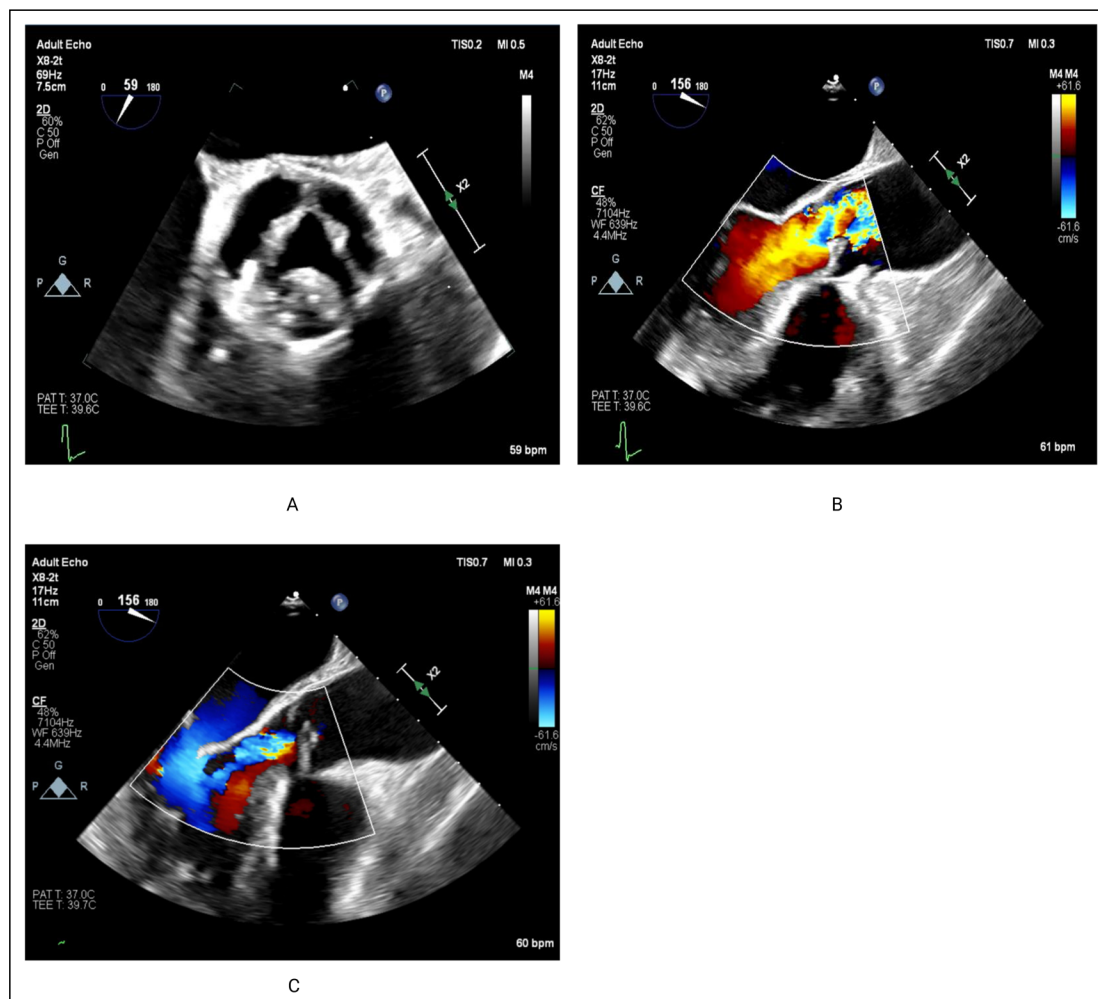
Transesophageal echocardiography findings. (A) Short-axis view of the aortic valve in systole demonstrating restricted leaflet opening with severe leaflet remodeling. (B) Long-axis view demonstrating aliasing at the level of the aortic valve before surgical intervention. (C) Long-axis view showing moderate aortic regurgitation.
